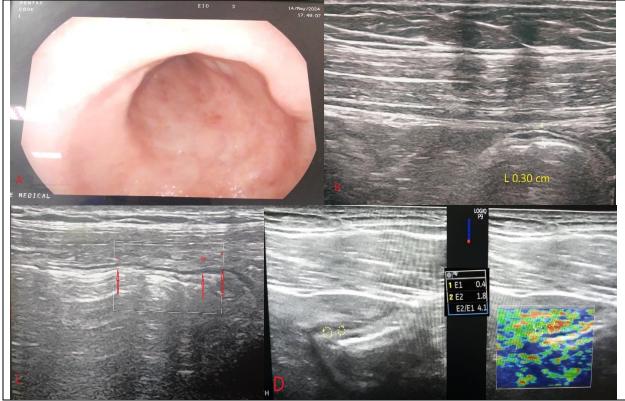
A 41 year old male patient, known UC on medical treatment not achieving complete remission, (A) colonscopic colonscopic picture of rectosigmoid showing mild erythematous mucosa with no exudation or ulcer, Mayo score 1, (B) ultrasound appearance of rectosigmoid wall showing borderline thickened wall about 0.30 cm with preserved layer stratification, (c) color doppler of pericolic fat showing small spots, (D) shear wave elastography of the rectal wall measuring elastography wave E1 & E2 & SR.
